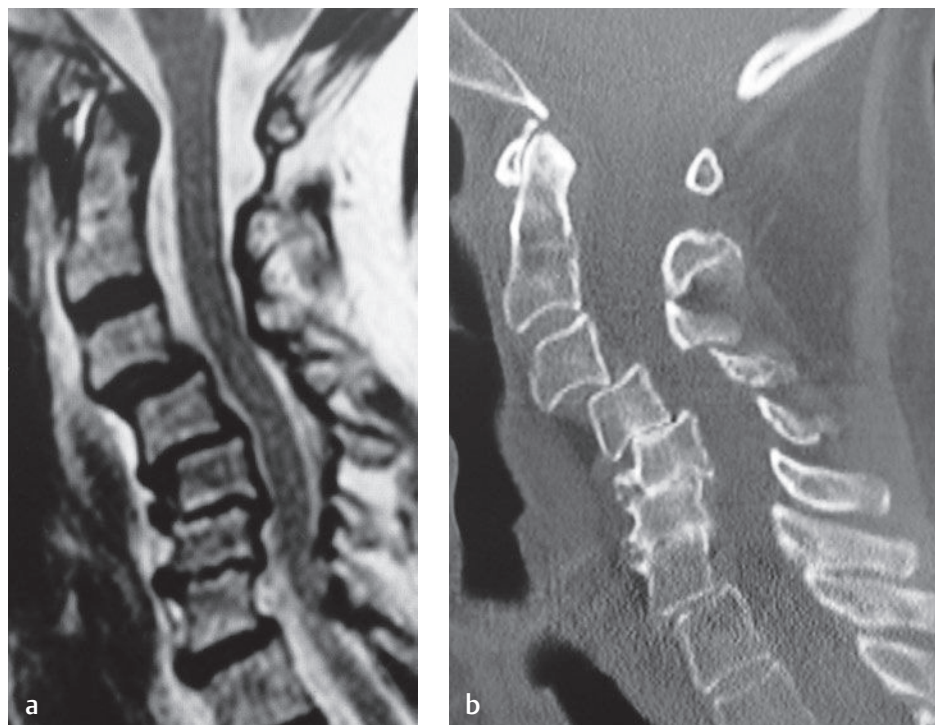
Subaxial subluxation in RA. (a) Sagittal T2-weighted and (b) sagittal reconstructed CT images show multilevel subaxial subluxation and degenerative disc disease. Specifically, there is spondylolisthesis at C3-C4 and C4-C5 and retrolisthesis at C5-C6. Note the improved osseous detail provided by the CT image compared with the MR image.[†]
